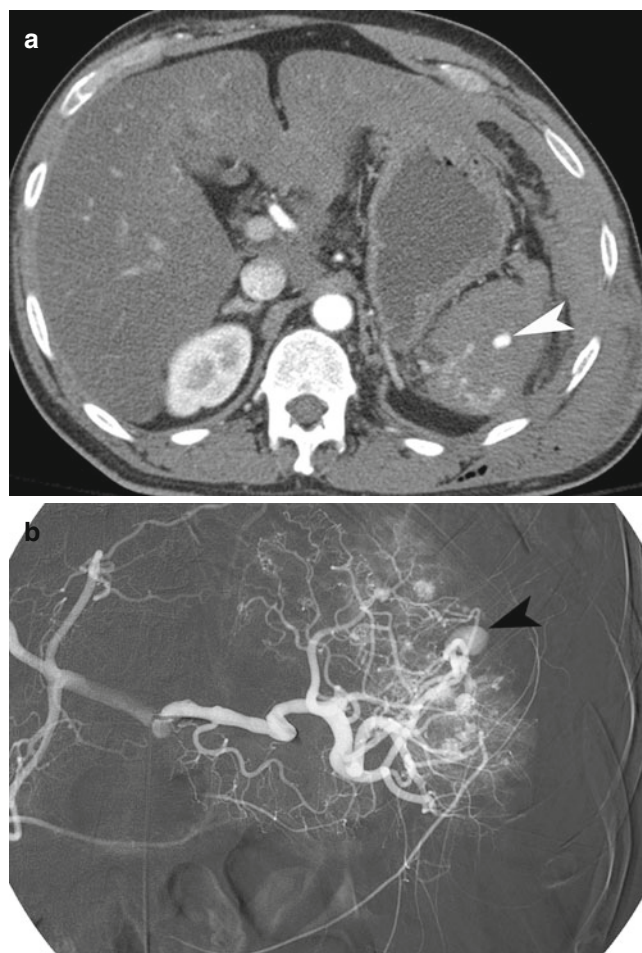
Splenic pseudoaneurysm. (a) Contrast-enhanced CT demonstrates a pseudoaneurysm (*arrowhead*) within the splenic parenchymal laceration. (b) Conventional splenic artery angiogram demonstrates the splenic arterial branch pseudoaneurysm (*arrowhead*)
